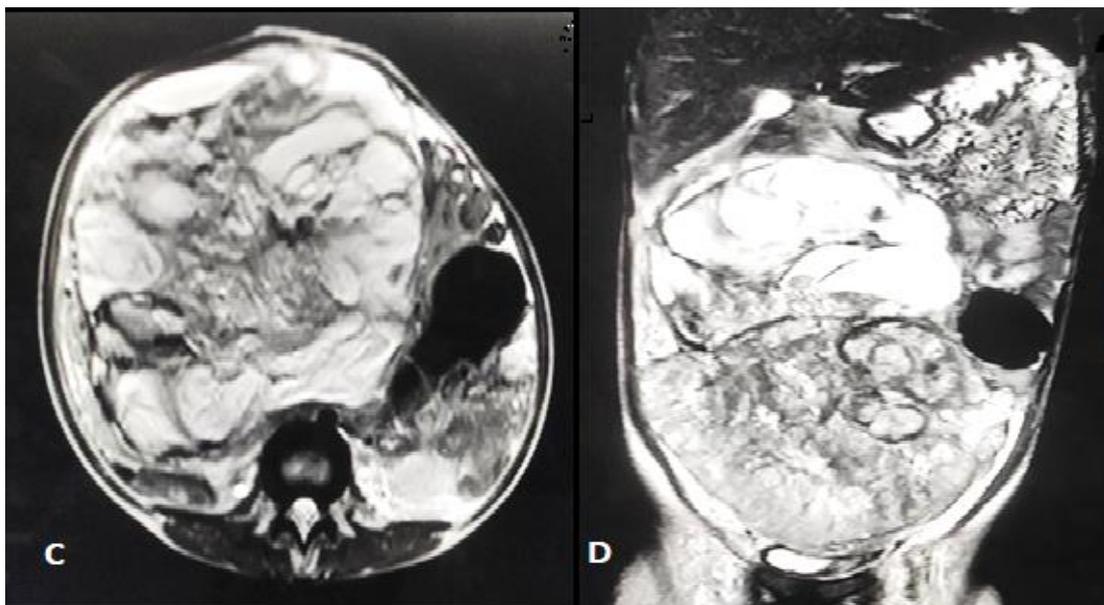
(C& D) T2 axial MR image shows a large lobulated heterogeneous solid mass with intralesional T2 hyperintense cystic component and a few areas of fatty component which got suppressed on STIR sequence (not shown) in the same female patient. On HPE the lesion was identified as a Germ cell tumor.
